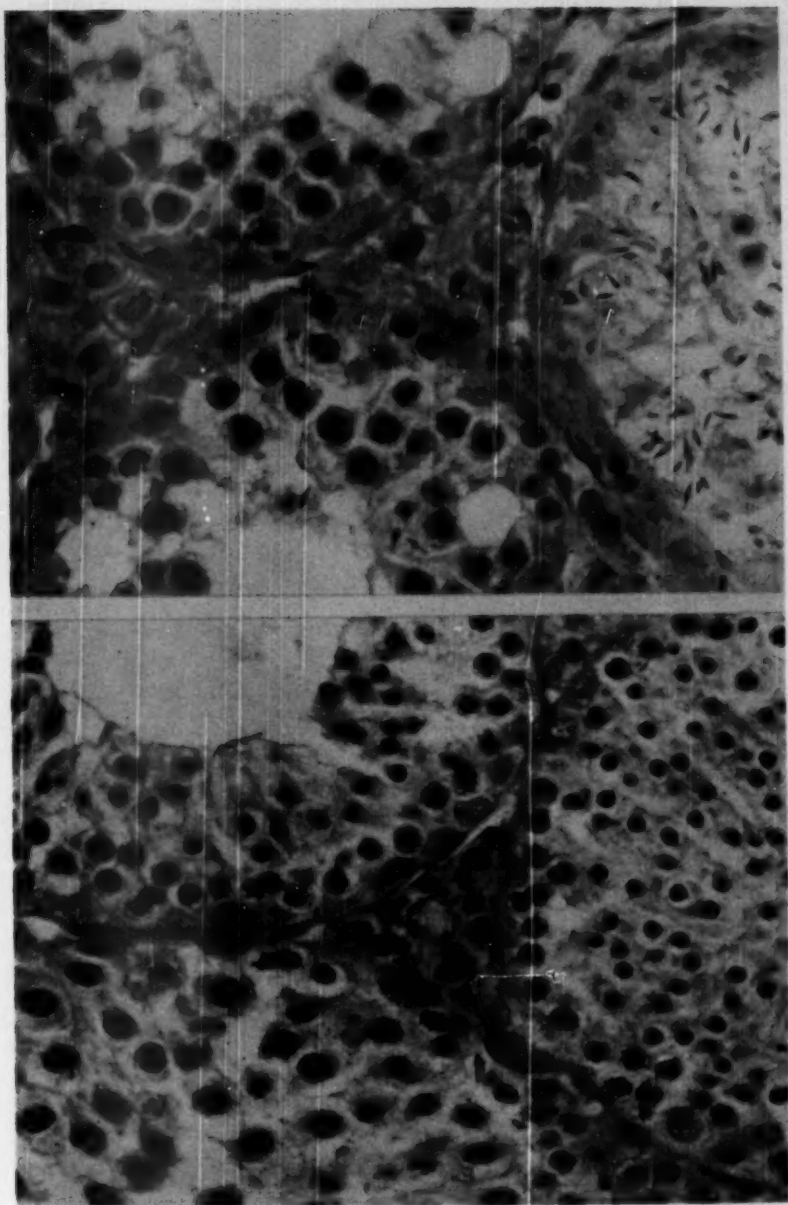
Upper part: Portions of three representative seminiferous tubules of a testis four weeks after whole body exposure to 400 r of roentgen radiation. The population consists of spermatogonia, spermatocytes and spermatozoa. There is an absence of spermatids. $\times 700$.
